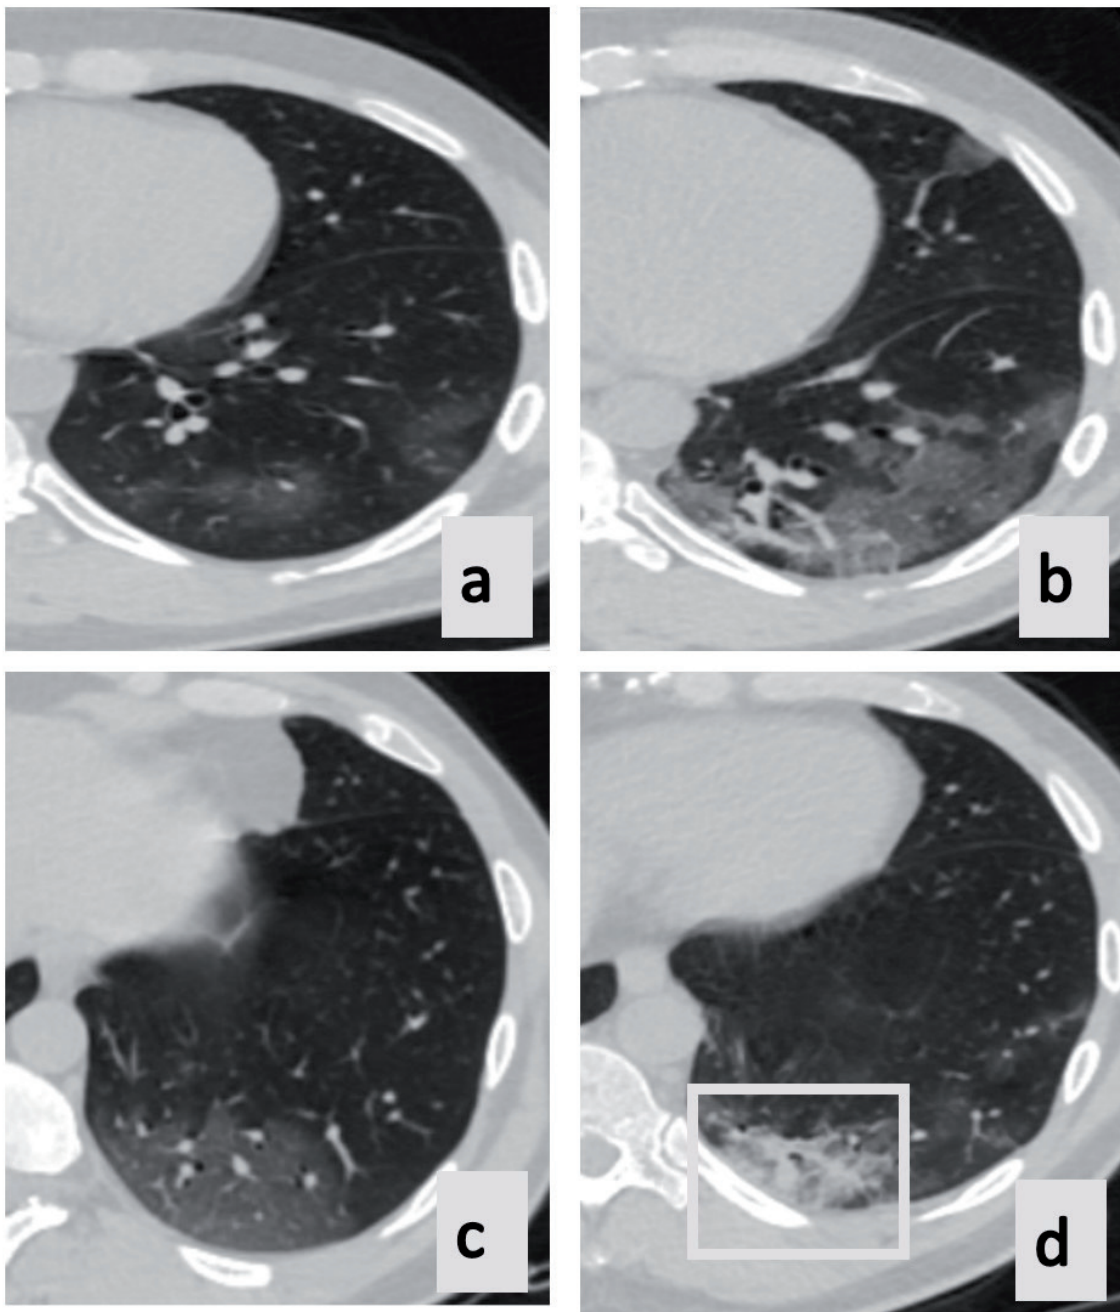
(a-d) 44 year old male patient, it was noteworthy that in the first examination (a), the GGOs observed in the lower lobe of the left lung expanded in the control examination on *in vivo* non-contrasted axial CT images obtained with an interval of 4 days (b). In the control evaluation in the ground glass area (c) located in the left lobe lower lobe posterobasal segment, fibrous bands developed (d).
